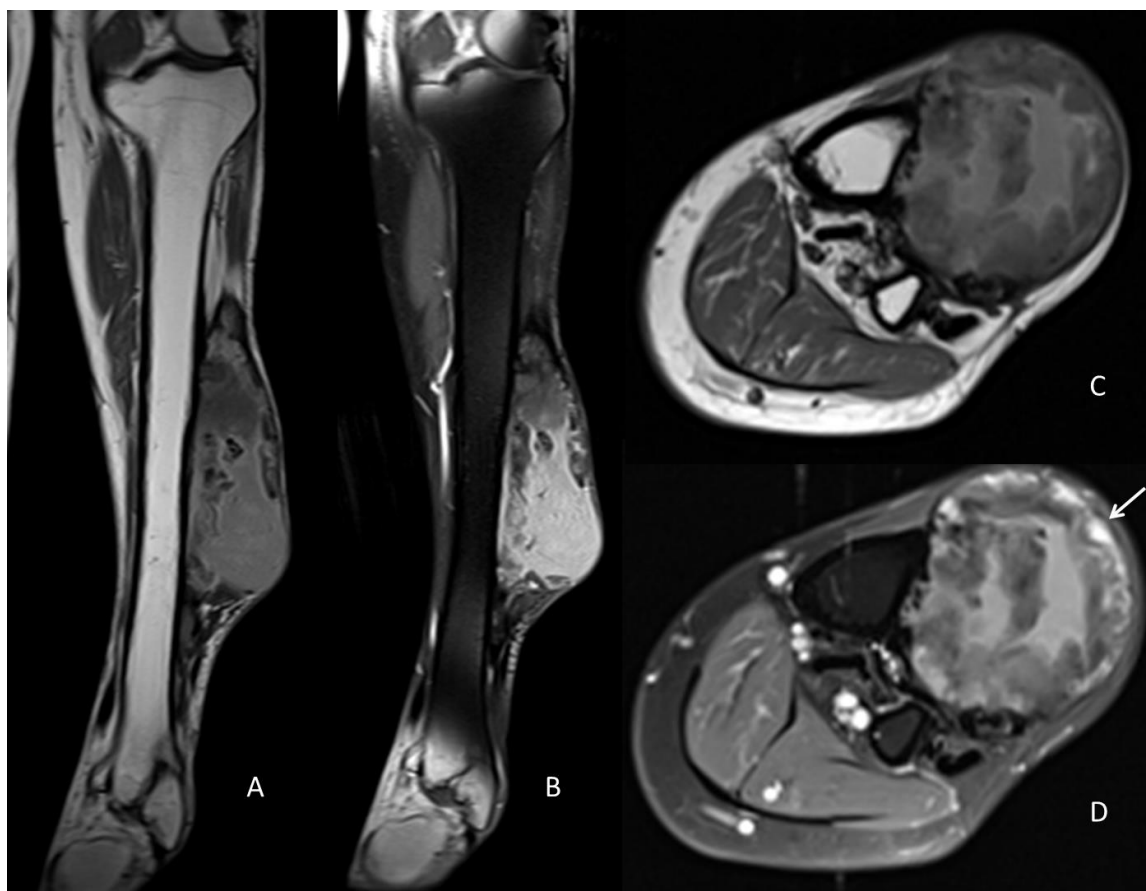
A 52-year-old male with chronic tophaceous gout. T1-weighted coronal (A) and axial (C) magnetic resonance sequences. T1-weighted fat-saturated post-contrast coronal (B) and axial (D) magnetic resonance sequences. The mass is heterogeneously iso to hypointense with patchy enhancement seen along its margins (arrow). This peripheral enhancement can be seen in cases of gout. Technical parameters: Siemens AERA 1.5T, T1-weighted coronal image (TR=516; TE=9); T1-weighted axial image (TR=520; TE=11); T1-weighted fat-saturated post-contrast coronal image (TR=532; TE=9) and axial image (TR=699; TE=11), Dotarem 12ml.
